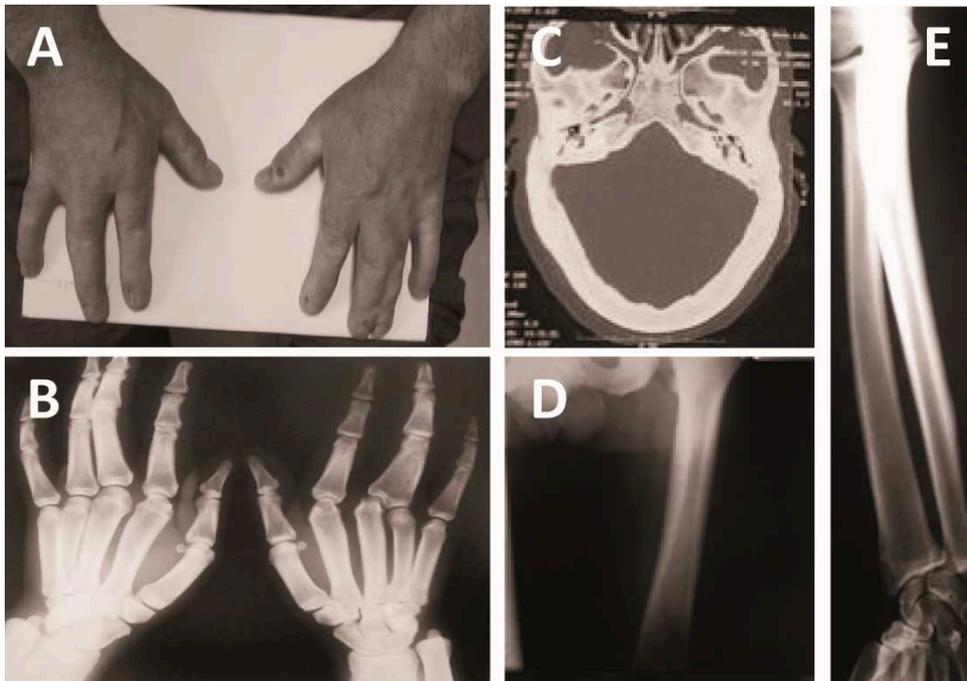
Clinical and radiographic features of the proband. A+B: Clinical photo and radiograph of the patient's hands. There is a complete osseous fusion of the third and fourth proximal phalanx on the left side resulting in a single digit. The third and fourth fingers on the right side show cutaneous syndactyly. C: CT scan of the skull showing a thickened calvarium. D: Radiograph showing sclerosis of the femur. E: Radiograph showing sclerosis of the radius and ulna.
